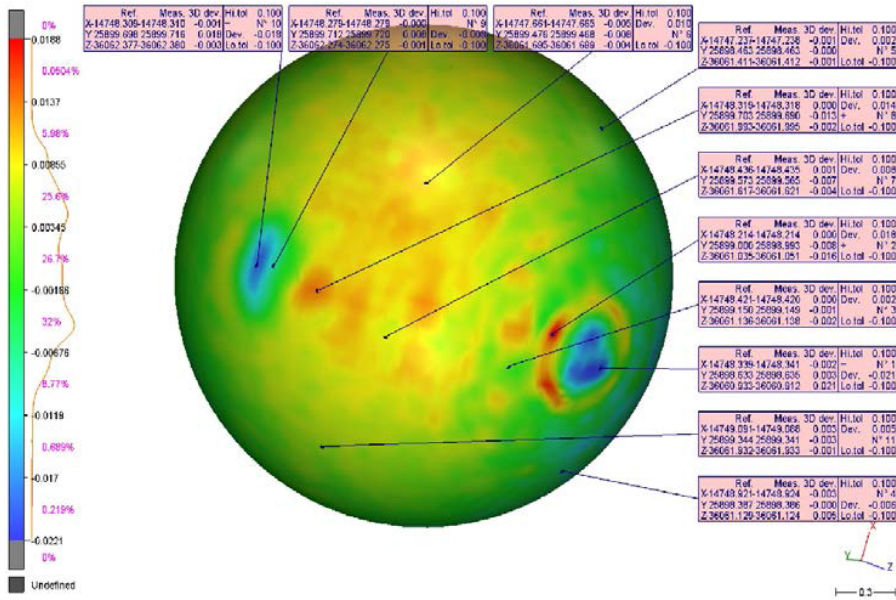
A map of imaging precision for the ceramic ball surface, subject to CT investigations and reconstructed in 3D Reshaper, compared to an ideal CAD
